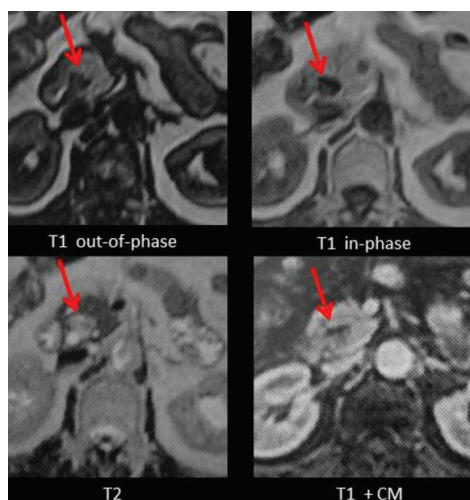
MRI of the pancreas: Duodenal diverticulum
